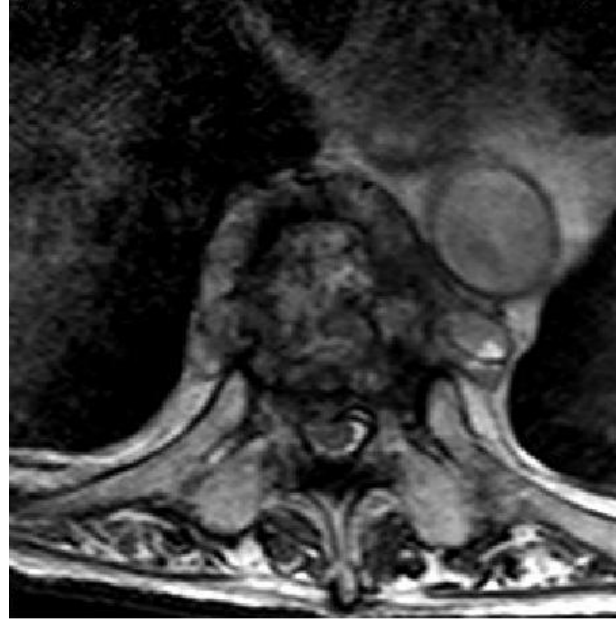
CT scan showing T10 osteomyelitis, transverse plane.
